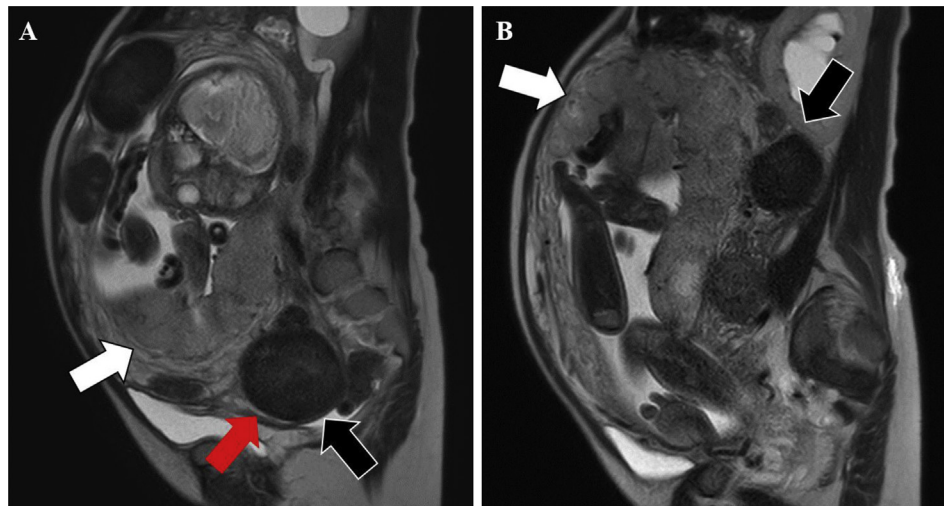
A: Magnetic resonance imaging (MRI) scan at 32 weeks of gestation. The uterine cervix was detected (red arrow). The placenta was located on the lower uterine segment as if it was a placenta previa (white arrow). Uterine leiomyoma with a diameter of 7 cm appeared to be cervical leiomyoma (black arrow). B: MRI scan at 35 weeks of gestation showing that the incarcerated uterus had been restored.
